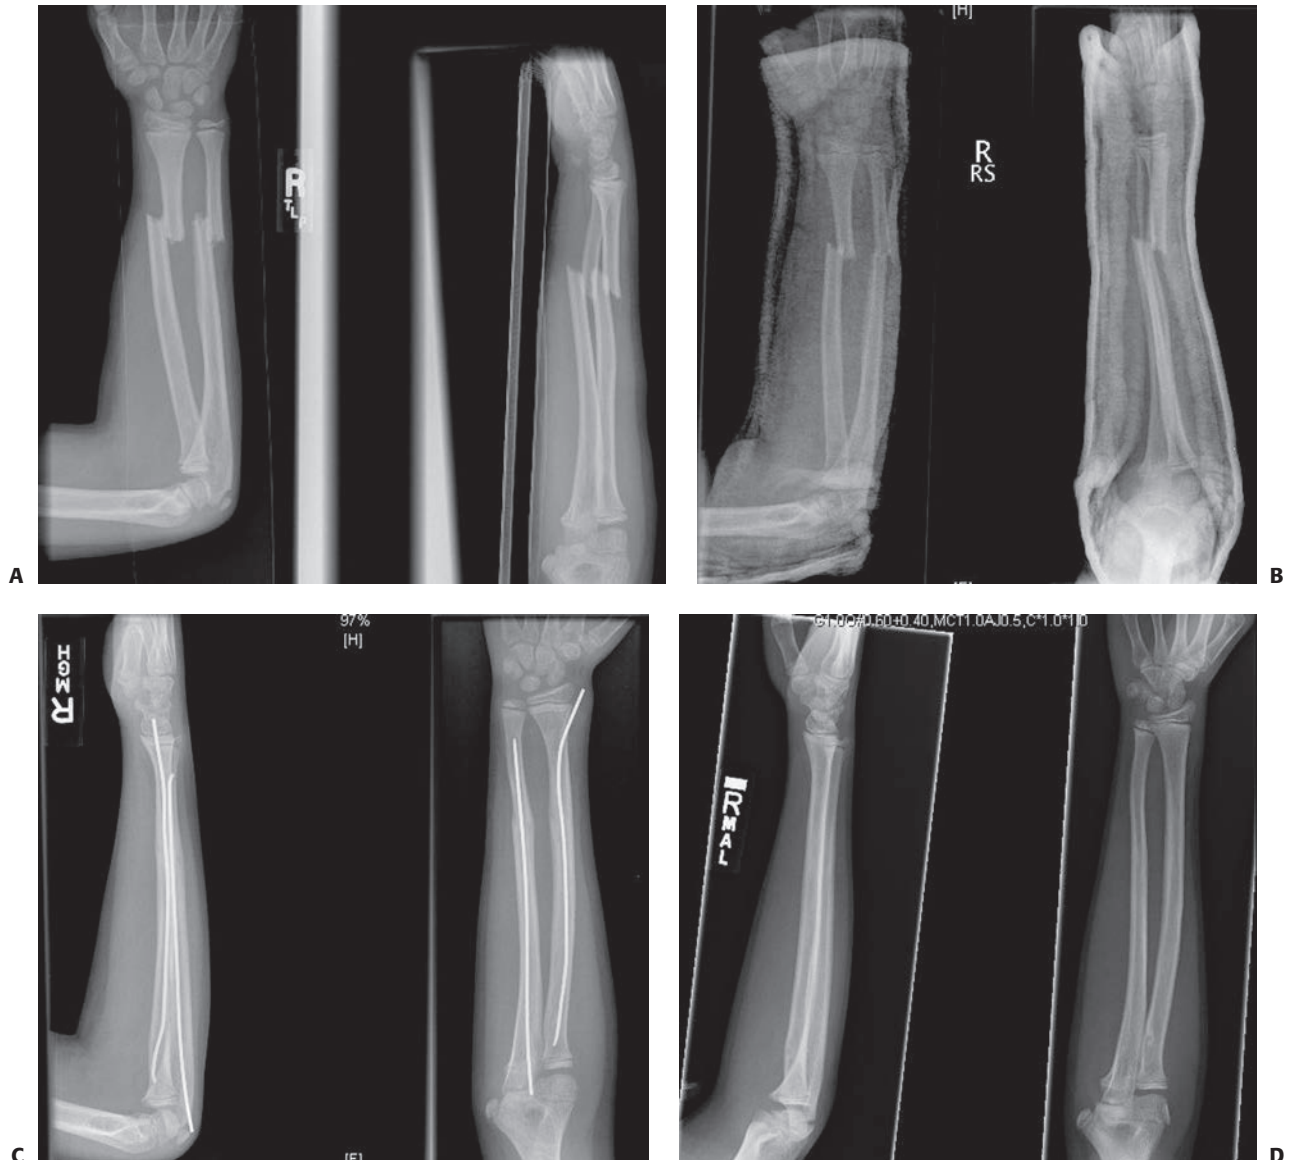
A 10-year-old male whose both bone complete forearm fracture near the junction of the middle and distal thirds was treated with elastic stable intramedullary nailing (ESIN). A: Injury radiographs demonstrating completely displaced radial and ulnar shaft fractures. B: Postreduction radiographs reveal unsatisfactory angular alignment as well as significant loss of radial bow. C: Anatomic appearance following ESIN. D: One-and-a-half-year follow-up radiographs. Nails were removed 6 months postoperatively.
